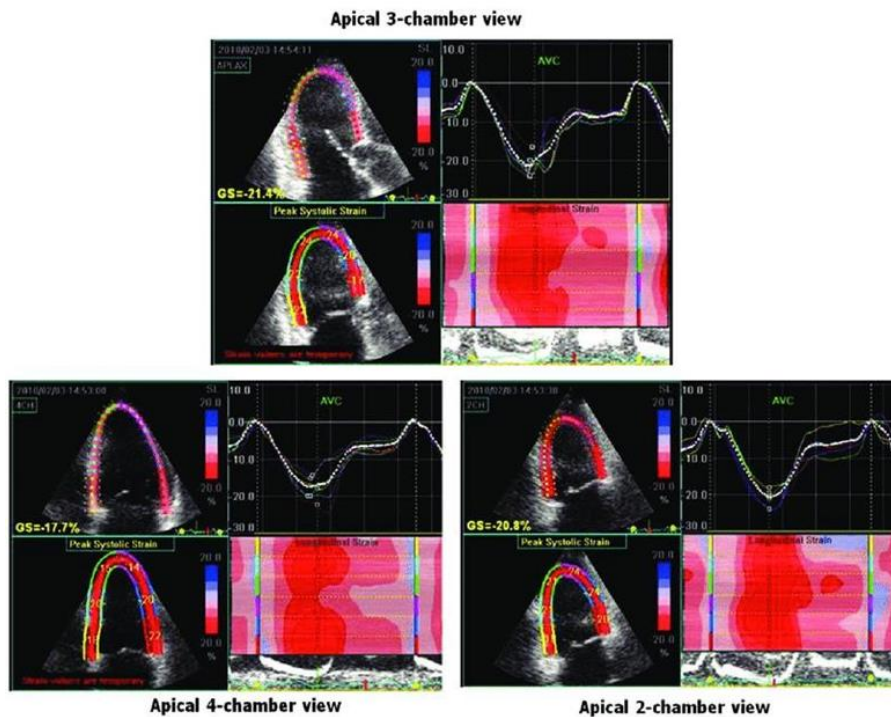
Speckle-tracking-echocardiography-STE-derived-left-ventricular longitudinal-strain(24).
